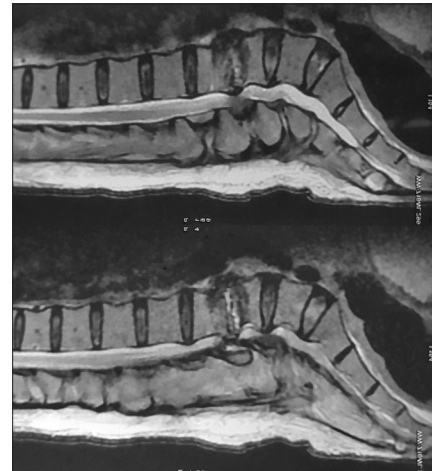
Magnetic resonance imaging sagittal view of the lumbosacral region showing wedged collapse of the L3 and L4 with herniation of the disc content causing severe canal stenosis
